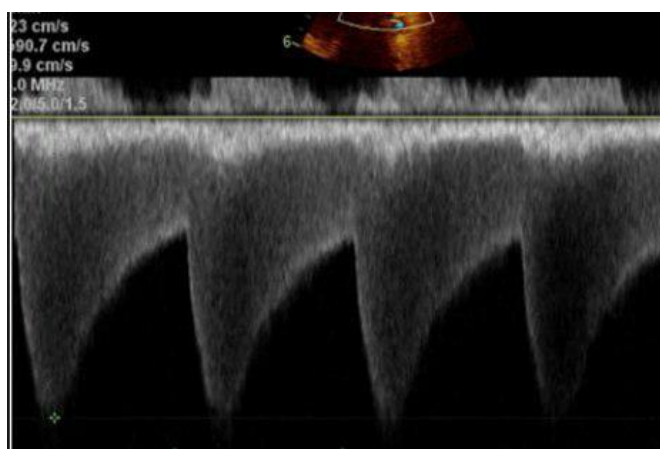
Doppler spectral echocardiography showed saw tooth appearance in neonate.
